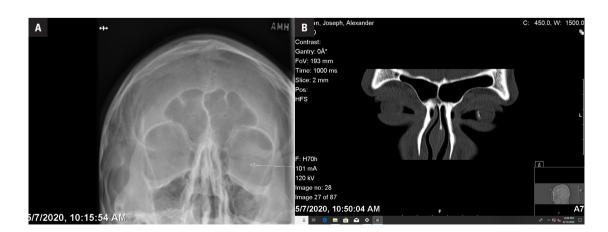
A. X-ray of the face shows the intraocular foreign body (indicated by arrow). B. Computed tomography (CT) scan of the skull shows the presence of the intraocular foreign body
